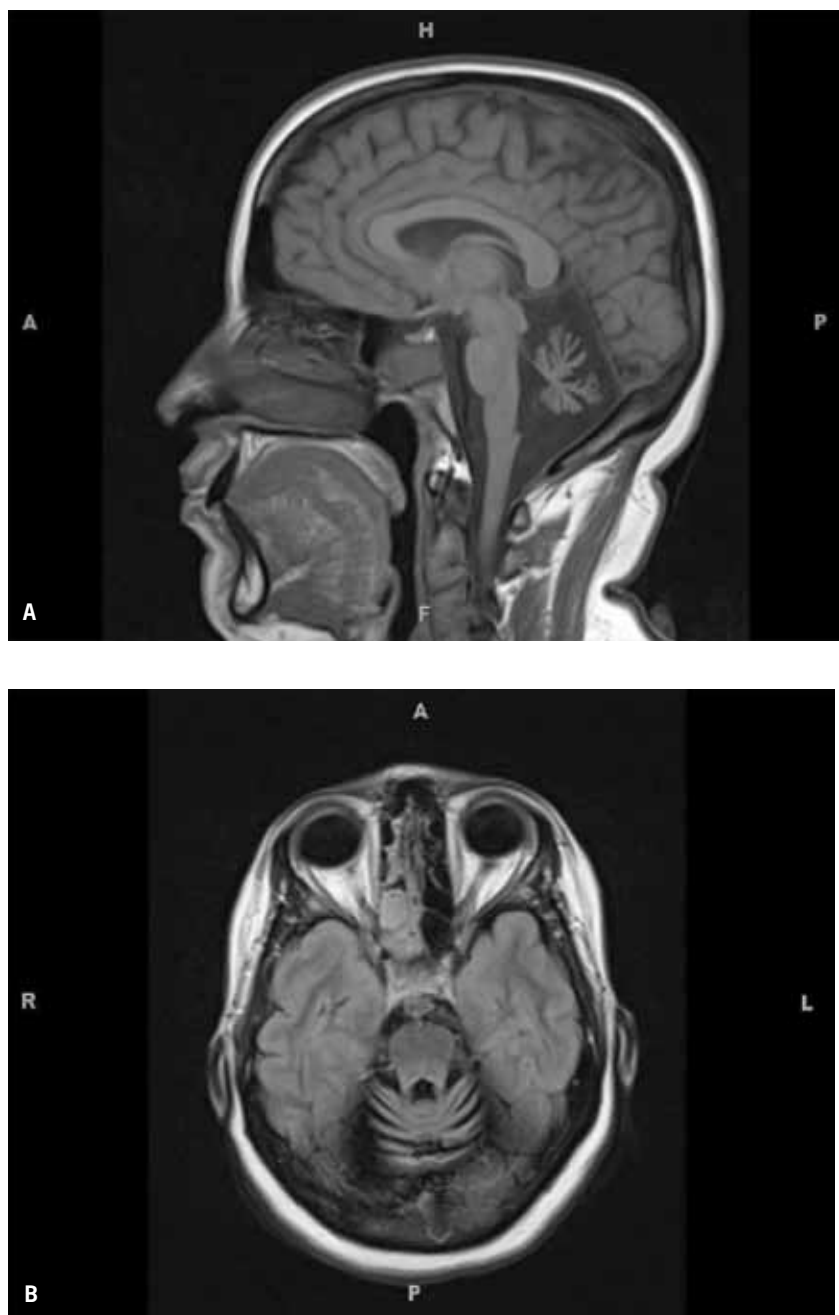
Cerebellopontine atrophy seen on a sagittal view (A) and axial view (B) of a magnetic resonance imaging scan of the brain.
